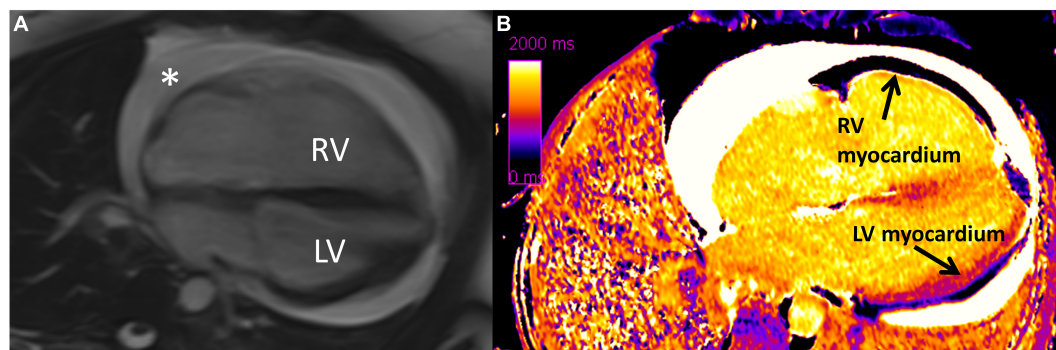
Diffuse interstitial fibrosis of the right ventricle using cardiovascular magnetic resonance imaging. (A) Four chamber cine showing enlarged right ventricle and circumferential pericardial effusion (*). (B) Native T1 map showing increased T1 time (diffuse fibrosis) in right ventricular myocardium compared to left ventricular myocardium. RV, right ventricle; LV, left ventricle. Note: this image is reproduced with permission from Belin et al. (11).
